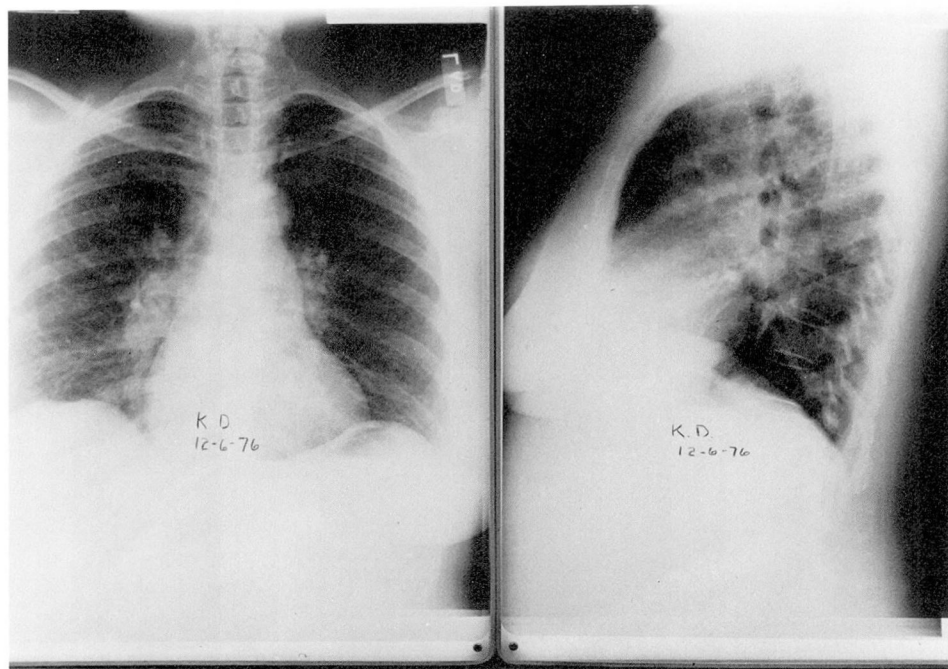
Posteroanterior and lateral chest roentgenograms of patient with misdiagnosed COPD. Note normal to small lung volume, best appreciated on lateral view and prominent hilar shadows, which were both enlarged pulmonary arteries and noncaseating hilar lymphadenopathy, i.e., sarcoidosis.
